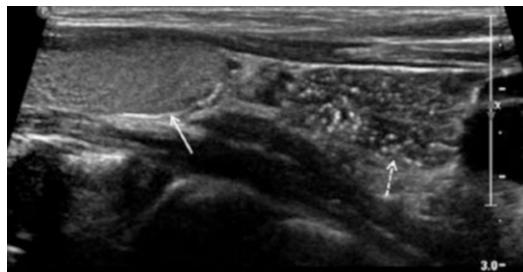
Sagittal ultrasound image of the neck of a 10-year-old boy, showing the left lobe of the thyroid (solid arrow) with adjacent ectopic thymic tissue (dashed arrow), demonstrating typical thymic echotexture (“dot-dash” pattern)
